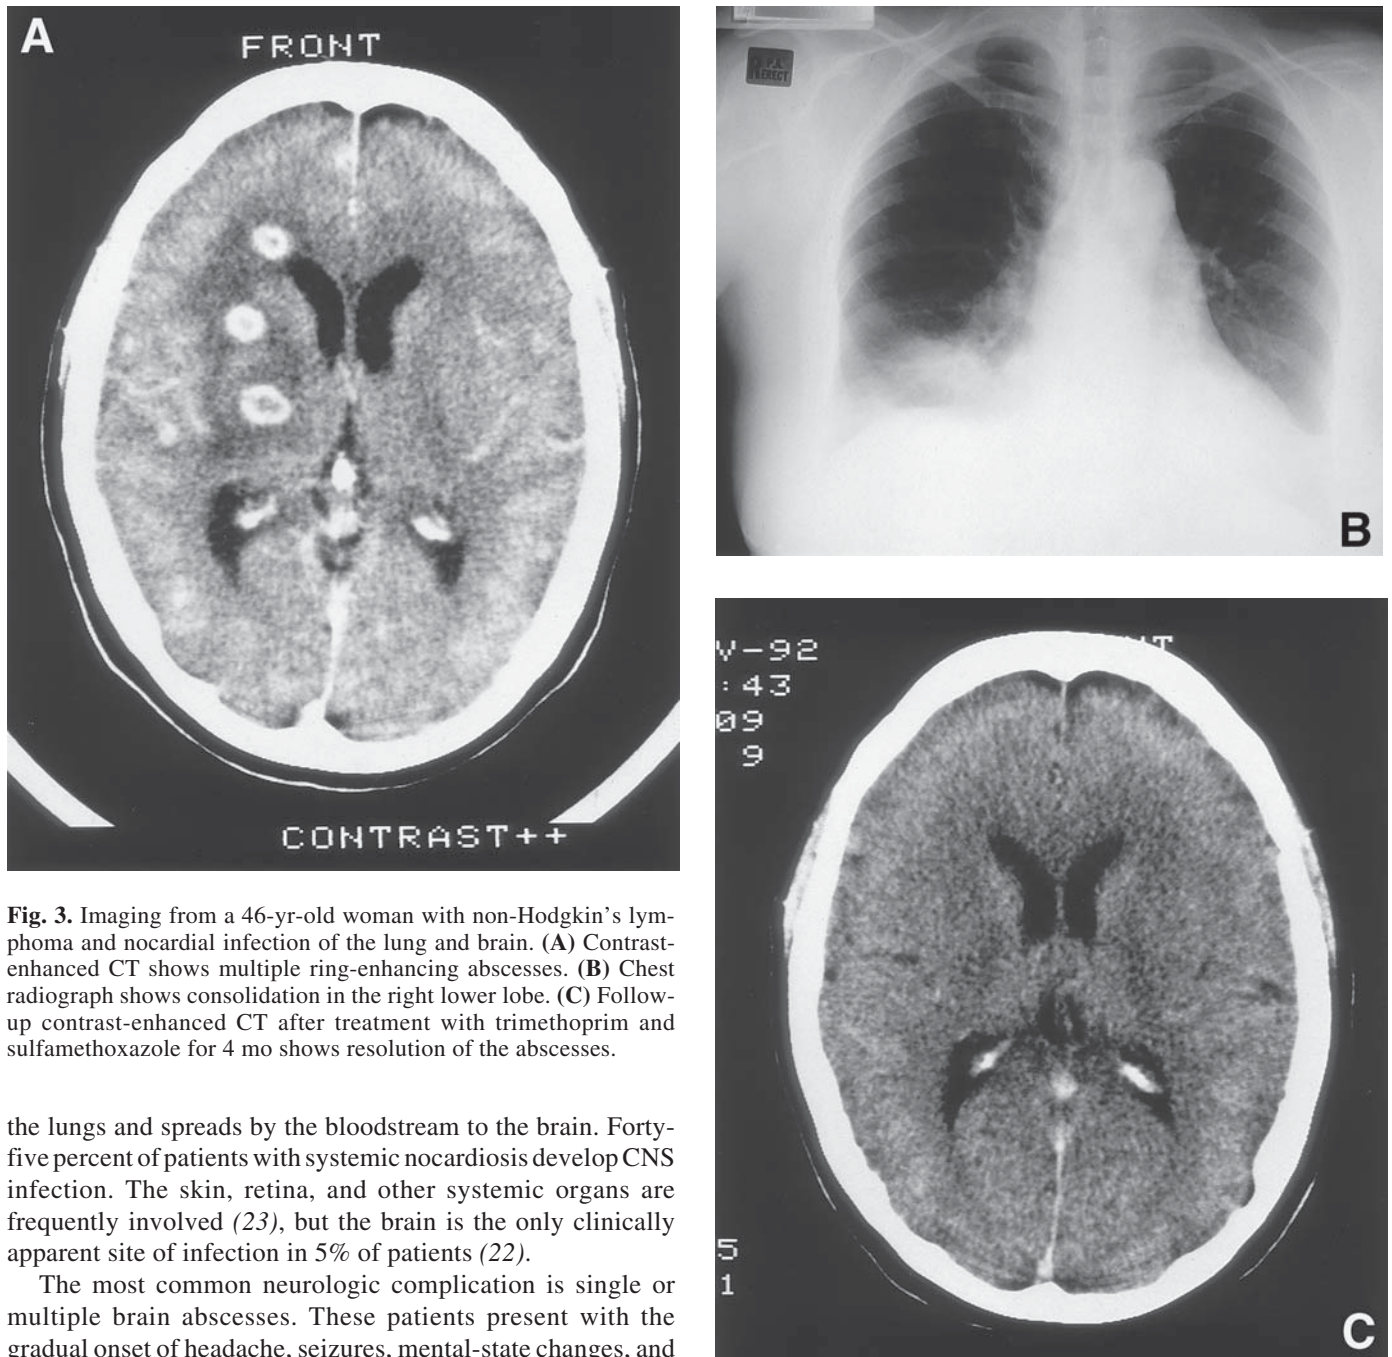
Imaging from a 46-yr-old woman with non-Hodgkin's lymphoma and nocardial infection of the lung and brain. (A) Contrast-enhanced CT shows multiple ring-enhancing abscesses. (B) Chest radiograph shows consolidation in the right lower lobe. (C) Follow-up contrast-enhanced CT after treatment with trimethoprim and sulfamethoxazole for 4 mo shows resolution of the abscesses.
